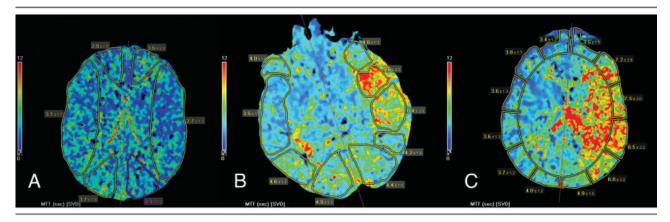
Identical computed tomographic perfusion imaging acquisition in three acute stroke cases shows how relatively subjective approaches may alter quantitative blood flow measurements on mean transit time (MTT) maps. Semiautomated approaches to map standard arterial territories such as the posterior cerebral artery (A) may yield erroneous values. Manually subsegmented portions of the middle cerebral artery territory (B) may show radically different values depending on choice of homologous region used as a control. Cortical regions are inadvertently ignored by measures (B) that attempt to avoid large-vessel influences. Measurements derived from automated region-of-interest sectors around the cortical surface (C) may ignore underlying vascular anatomy and fail to account for entire subcortical regions.
